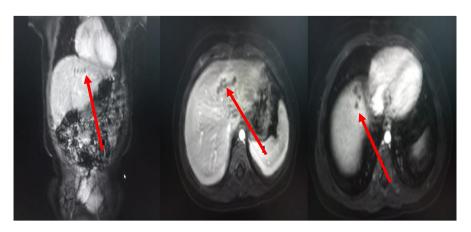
Contrast-enhanced abdominal magnetic resonance imaging shows a tubular non-enhancing area in segments IVa and II of the left lobe of the liver with peripheral mild to moderate enhancement in the liver parenchyma.
